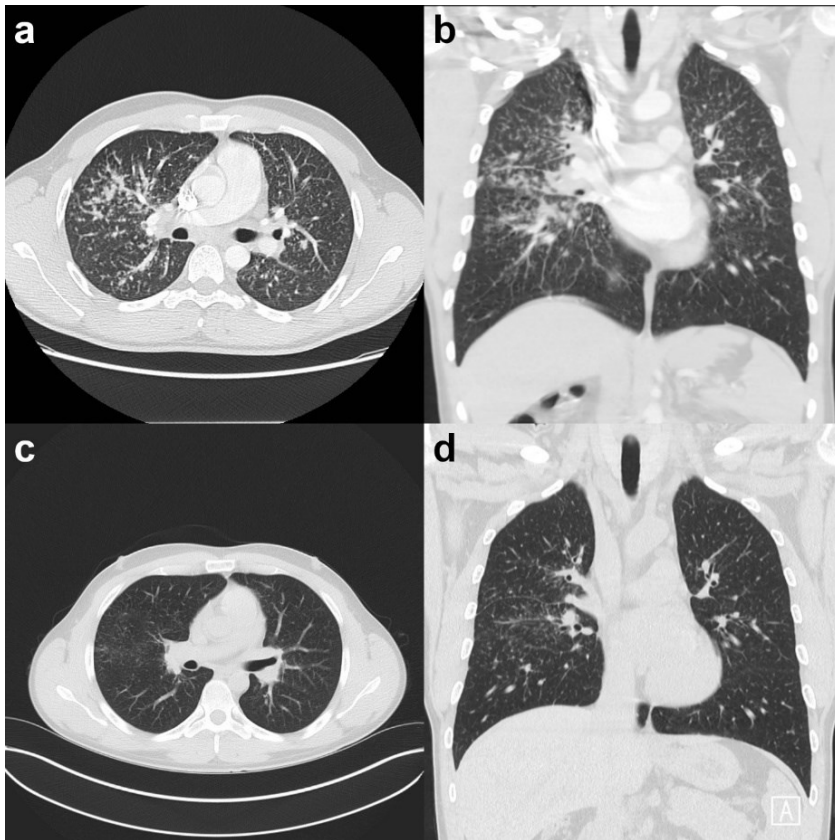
Case A: (a - b) High-resolution computed tomography (HRCT) from January 2013 showing multiple nodular lesions with a lymphatic distribution and enlarged mediastinal lymph nodes. (c - d) In January 2014, one year after removal from exposure, a HRCT scan showed regression of the nodular lesions.
